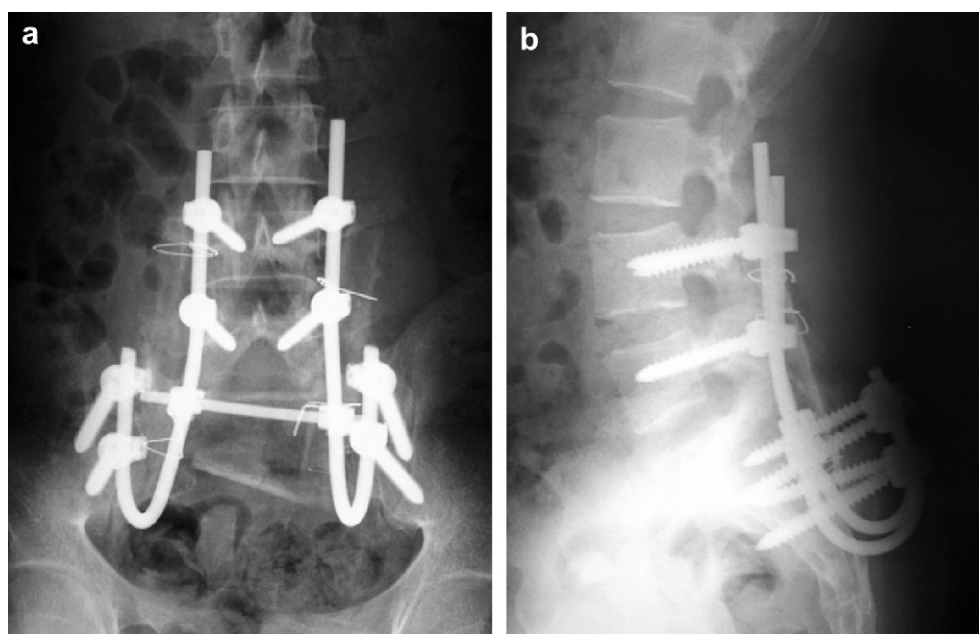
(a & b): The post-operative X-ray lumbo-sacral spine (antero-posterior and lateral views) of case 3 showing bilateral spinal fixation with two vertical rods transfixing polyaxial pedicle screws in L4, L5, S1, sacral ala, and ilium after excision of giant cell tumor (GCT). A cross link is placed between the two vertical bars.
